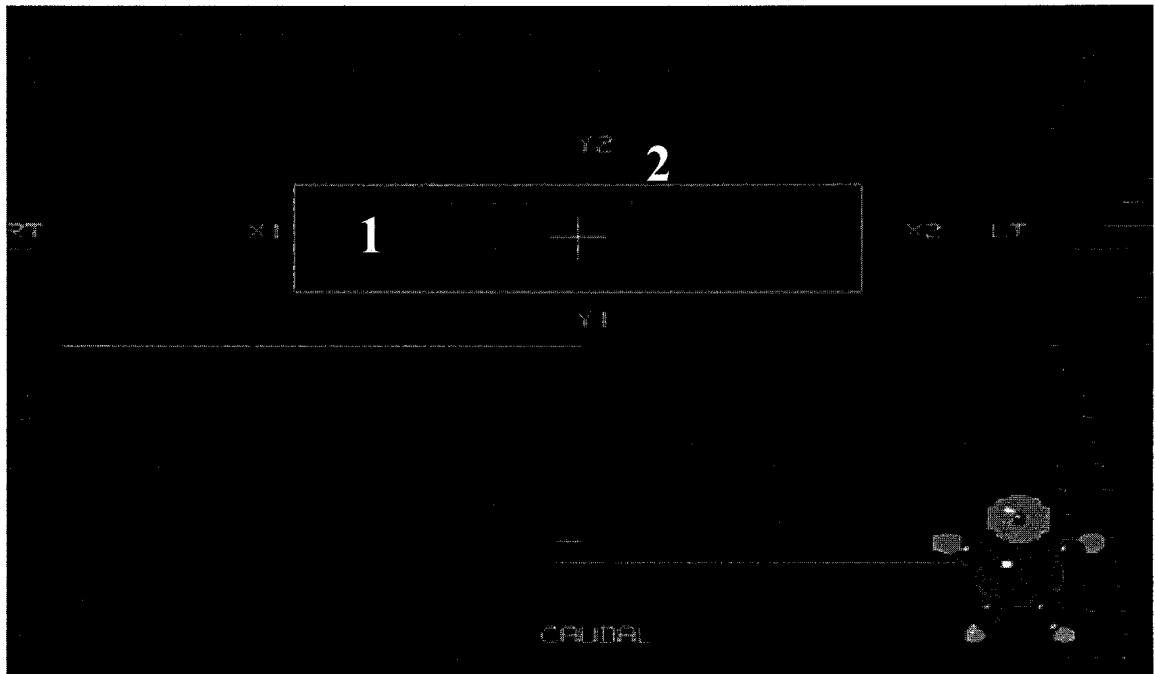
Coronal beam eye view of partial fields (1) covering only a few CT slices on which lie the cubic contour (2).
